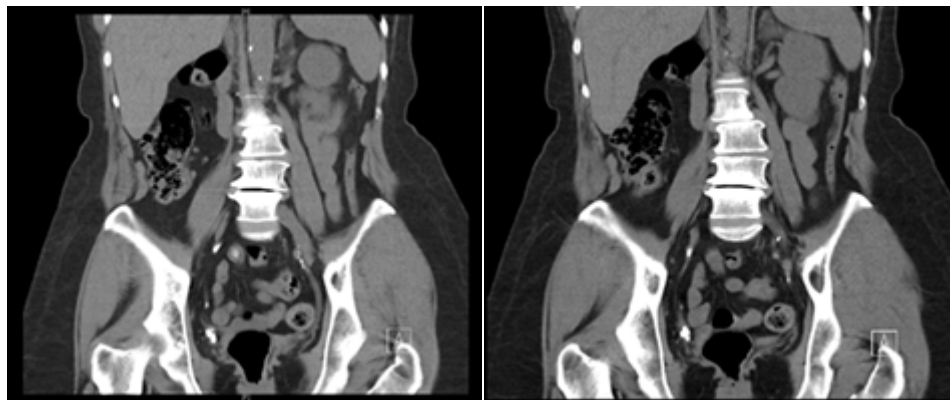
Unenhanced computed tomography showing multiple calculi with in right ureteric stump.
